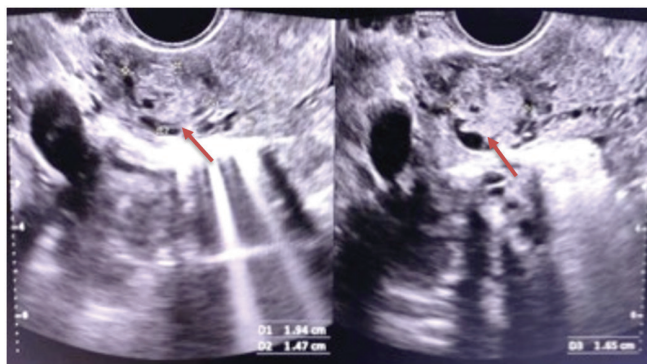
Initial transvaginal ultrasound, sagittal view showing a 1.94cm x 1.47cm x 1.65cm left adnexal mass (red arrow) probably ectopic pregnancy
